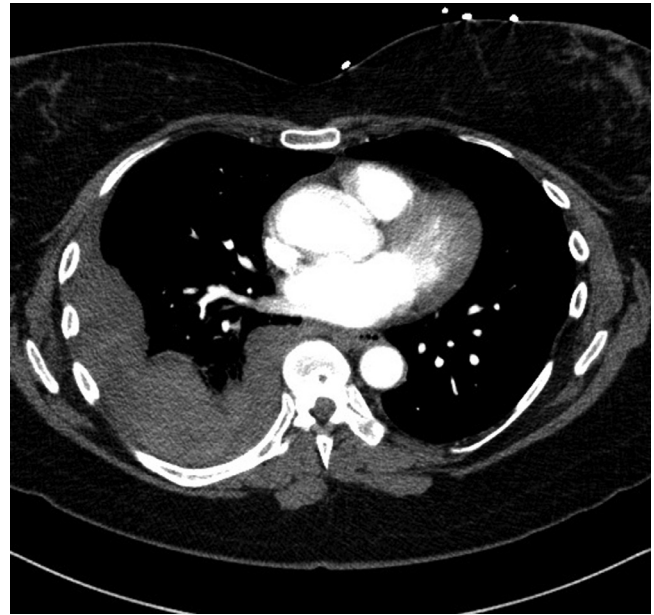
Axial contrast-enhanced CT of the chest (2 mm slice thickness, 100 mL IV Omnipaque 300): Mixed-density, loculated right pleural effusion consistent with a hemothorax.
